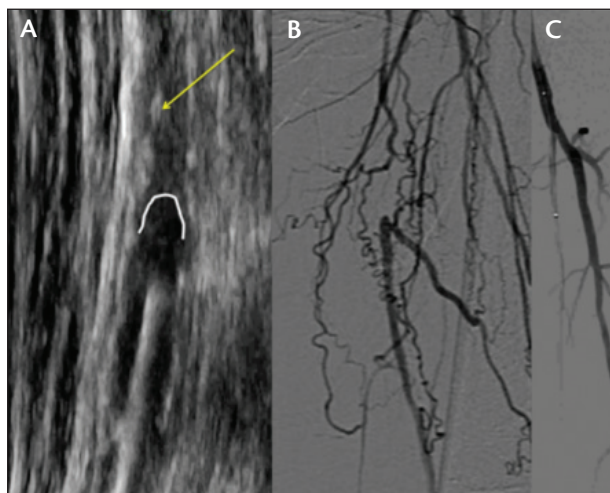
Extravascular ultrasound (EVUS) evaluation of the distal CTO cap defines the cap as retrograde concave and antegrade convex (white line) (A). This type of CTO is best approached from a retrograde access. The yellow arrow points to the plaque calcification (A). Angiographic evaluation of the CTO cap is consistent with the EVUS findings of antegrade convex and retrograde concave cap (B). Angiogram of the common femoral artery (CFA) and the superficial femoral artery (SFA) after retrograde crossing of the proximal SFA CTO (C).
